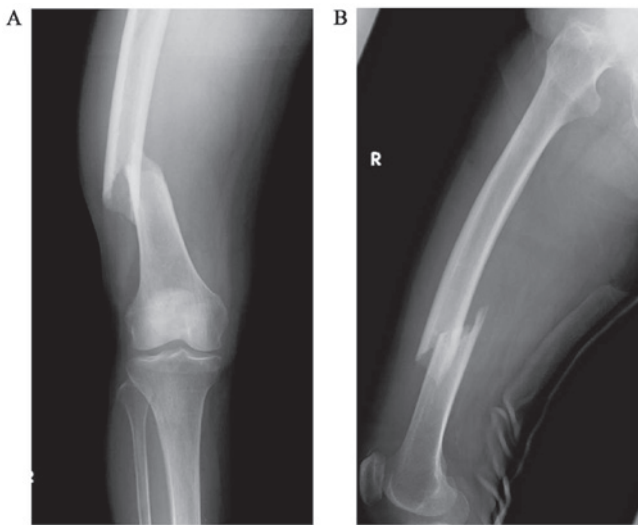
Preoperative radiographs. The patient visited a local hospital after a fall. Plain radiographs revealed a right femoral diaphyseal fracture at the time of initial presentation. The fracture site appeared rough, but there were no abnormal findings around the fracture site, such as periosteal reactions, osteolytic changes or osteoblastic changes. (A) Front view. (B) Side view.
